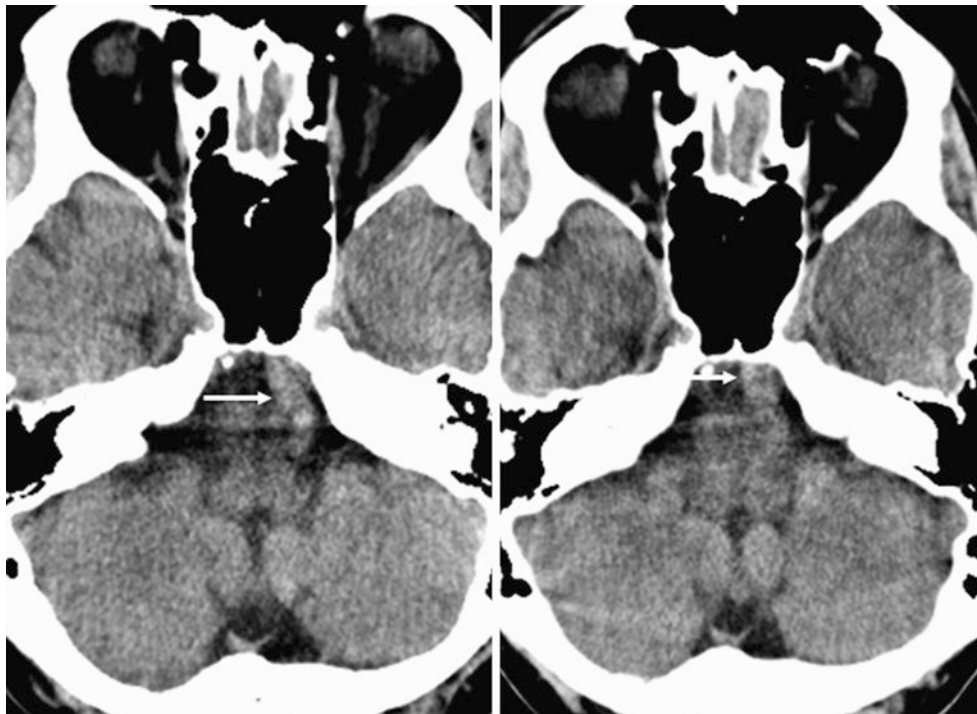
65-year-old with axial nonenhanced CT (*left*) that demonstrates moderate basilar artery dolichoectasia (diameter 7–8 mm). One year later (*right*), this diameter was unchanged (*arrows*). The patient did not have related symptoms
